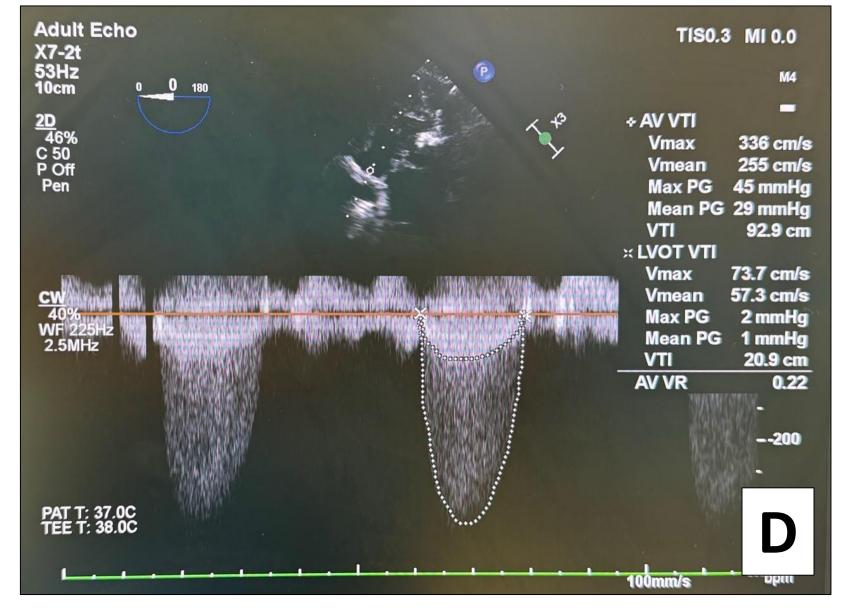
A & B) Transgastric mid-papillary short axis views at end-diastole & end-systole, C) Mid esophageal long axis view, D) Continuous wave Doppler interrogation of aortic valve and LV outflow tract in deep transgastric view, E) ProneView Protective Helmet System
